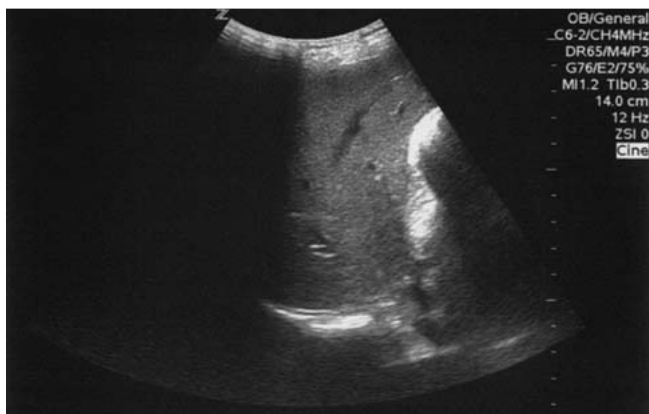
Upper abdominal ultrasound with visualisation of the liver. Echo-rich internal pattern with rounded liver margins.
